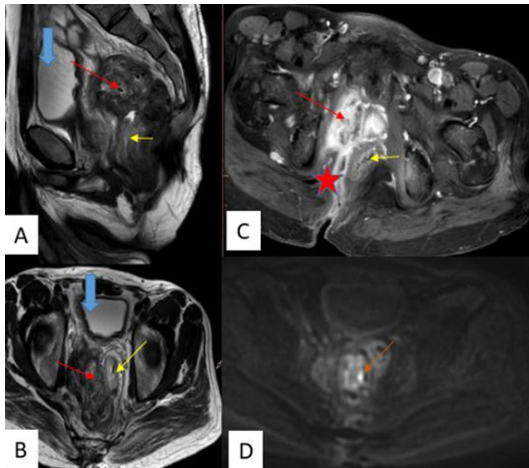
Abdominal MRI: Sagittal and axial T2 (A, B): retroperitoneal latero-recto-anal multilobulated mass with heterogeneous T2 hypointensity (red arrow), creating a mass effect on the left rectum (yellow arrow) and anal canal, and on the bladder anteriorly (blue arrow), coming into contact with the internal obturator muscle without clear signs of infiltration. T1 after injection of gadolinium (C), and diffusion B1000 (D). This process enhances heterogeneously after gadolinium injection (red arrow), with the identification of a fistulous tract between the tumor and the soft tissues of the buttocks (red star). Localized restriction is also observed on the diffusion sequence (orange arrow).
